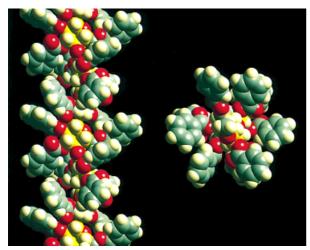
Optimized structure of CTB (24) based on the structure determined by X-ray analysis.^[45a] The energy minimization was carried out with the Dreiding force field in Cerius² (MSI). The glucose carbon atoms of CTB are shown in yellow for clarity. View along the helix axis (left) and perpendicular to the helix axis (right).
